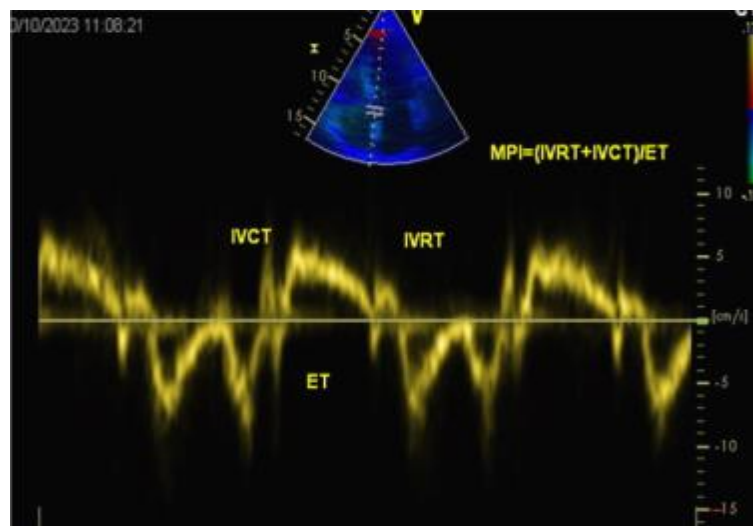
Calculation of tissue Doppler-derived left ventricular myocardial performance index.
